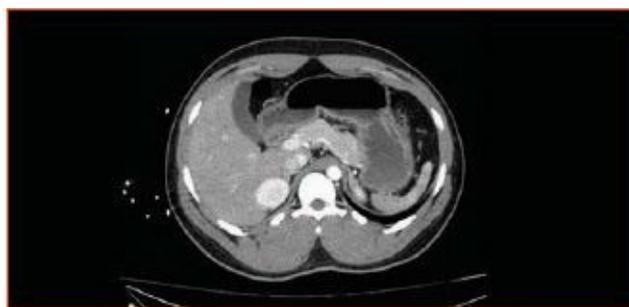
A normal abdominal computed tomographic scan.
